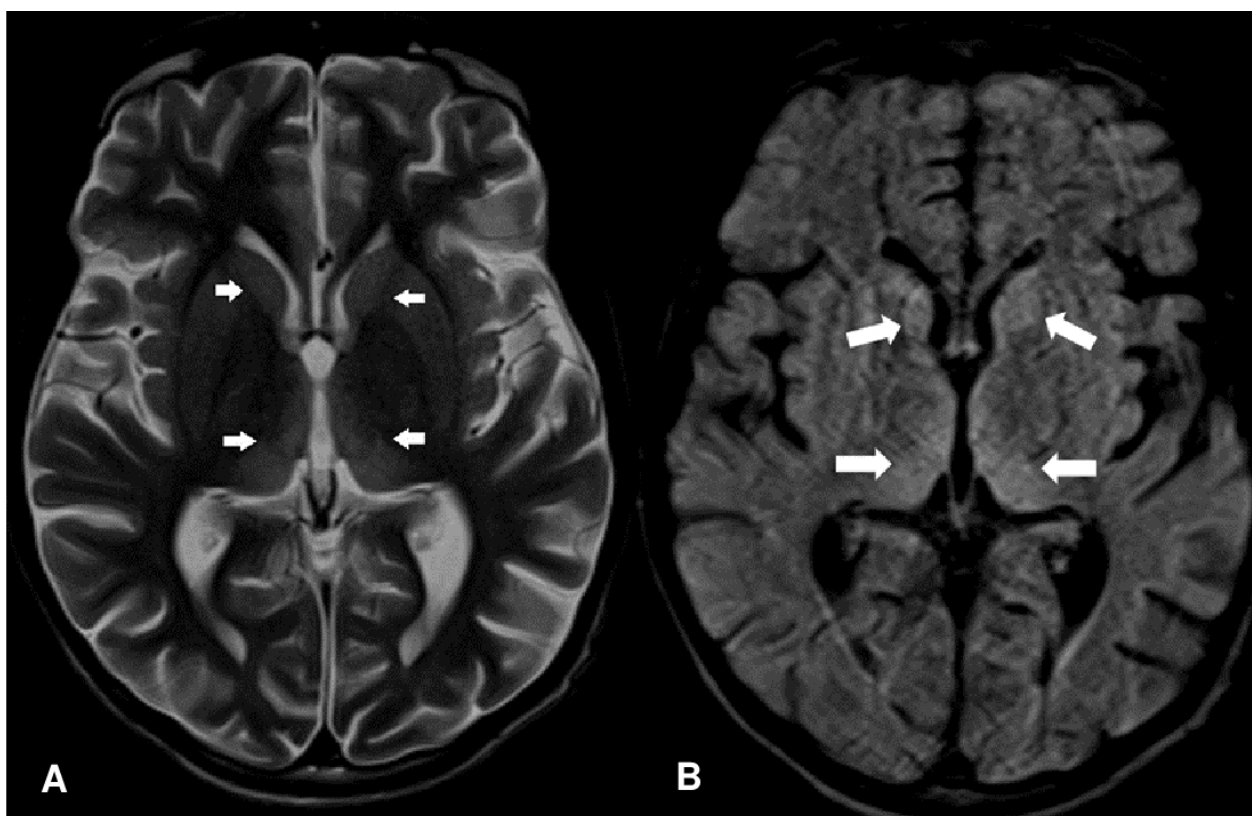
(a) The axial T2 and (b) FLAIR weighted imaging showed that abnormal high signal intensity in bilateral and symmetrical hyperintense lesions in pulvinar and dorsomedial thalami
